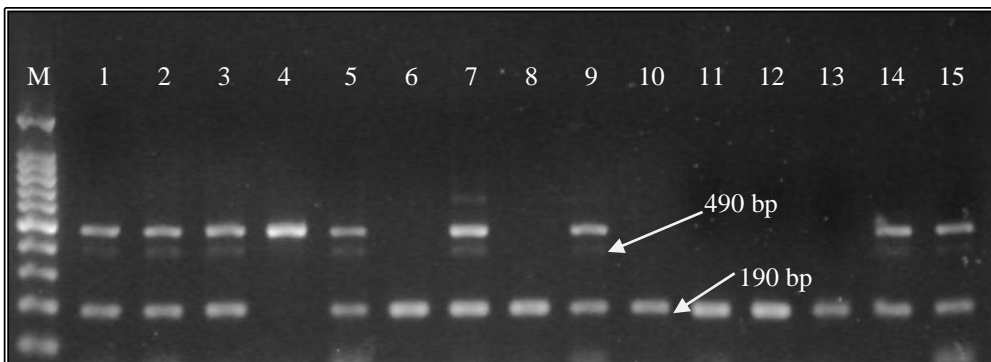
Representative gel profiles of ACE DI and MTHFR polymorphisms. A Lanes 1,3, and 5 show CC wild MTHFR, while lanes 2, 4, 6, and 7 show CT heterozygous MTHFR, w (wild primer), m (mutant primer).B; Lanes 1, 2, 3, 5, 7, 9, 14, and 15 show DI form; Lanes 6, 8, 10, 11, 12 and 13 show DD form; Lane 4 shows II form. M, Sizer™ -100 DNA Marker (iNTRON Biotechnology, Korea)
